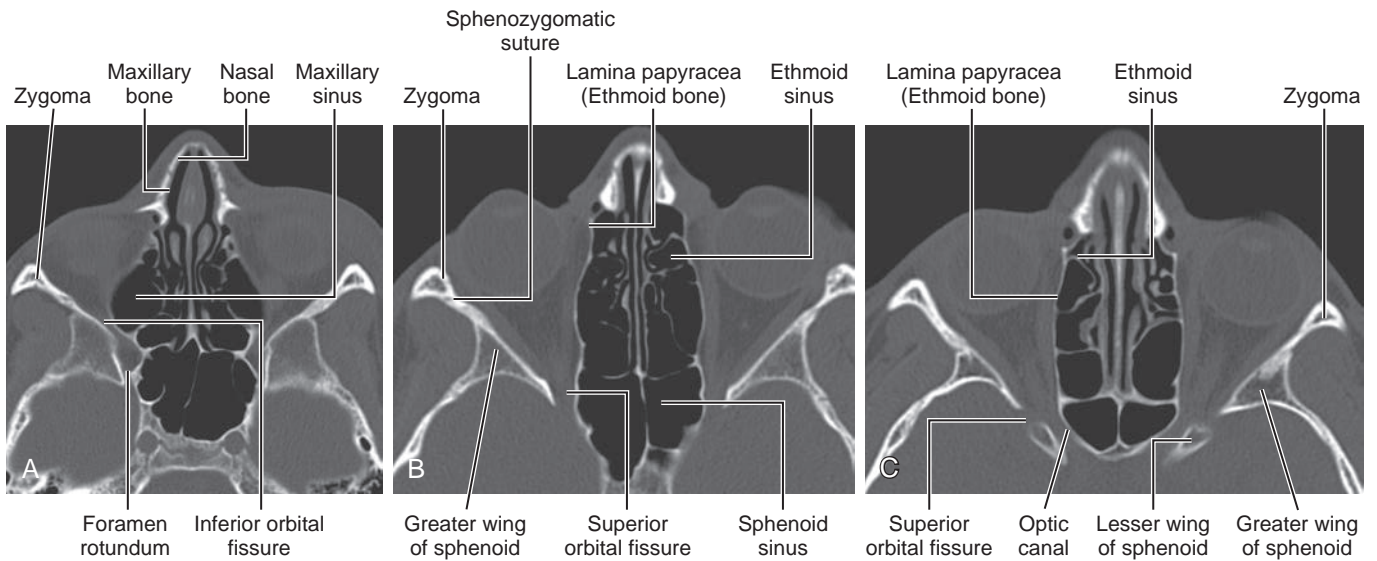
Axial anatomy of the bony orbit. (A–C) Axial noncontrast computed tomography images from inferior to superior location.
